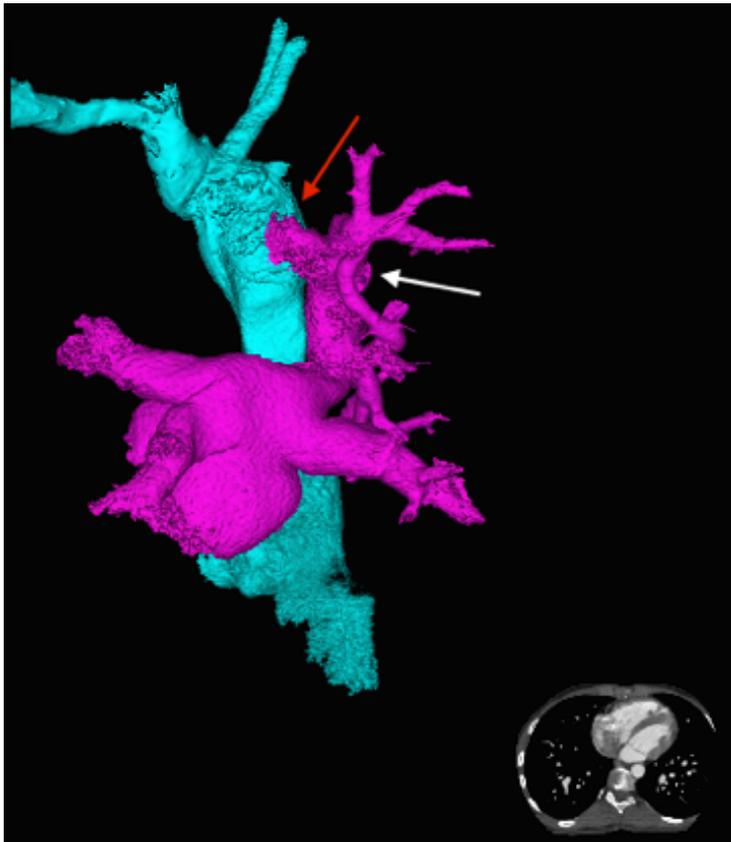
CT 3D reconstruction demonstrating pulmonary veins with left atrium (pink) and systemic veins with right atrium (blue). Also shown are the vertical vein (white arrow) and tributaries with connection (red arrow) of vertical vein and superior vena cava.
